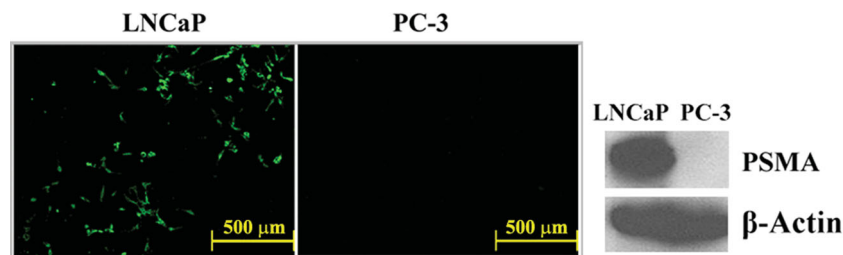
Expression of PSMA in prostate cancer cells. Left: LNCaP and PC-3 cells were fixed on slides, and incubated with anti-PSMA antibody and with FITC-labeled secondary antibody (green) sequentially. Right: Whole cell lysates from LNCaP and PC-3 cells were analyzed with Western blotting.
